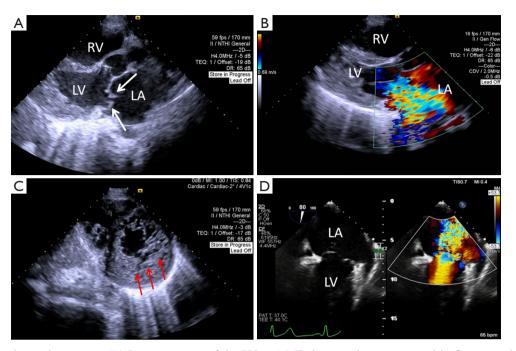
Echocardiographic images. (A) Long-axis view of the LV on TTE showing the entire mitral leaflet protruding into the LA during systole (white arrows indicate the prolapsed MV). (B) The long-axis view of the LV on TTE showing severe systolic MR. (C) The parasternal short-axis left ventricular apical view on TTE showing a ratio of noncompacted myocardium to dense myocardium of the ventricle greater than two (the red arrows indicate the noncompacted myocardium). (D) Intraoperative TEE showing severe systolic MR. RV, right ventricle; LV, left ventricle; LA, left atrium; TTE, transthoracic echocardiography; MV, mitral valve; MR, mitral regurgitation; TEE, transesophageal echocardiography.
